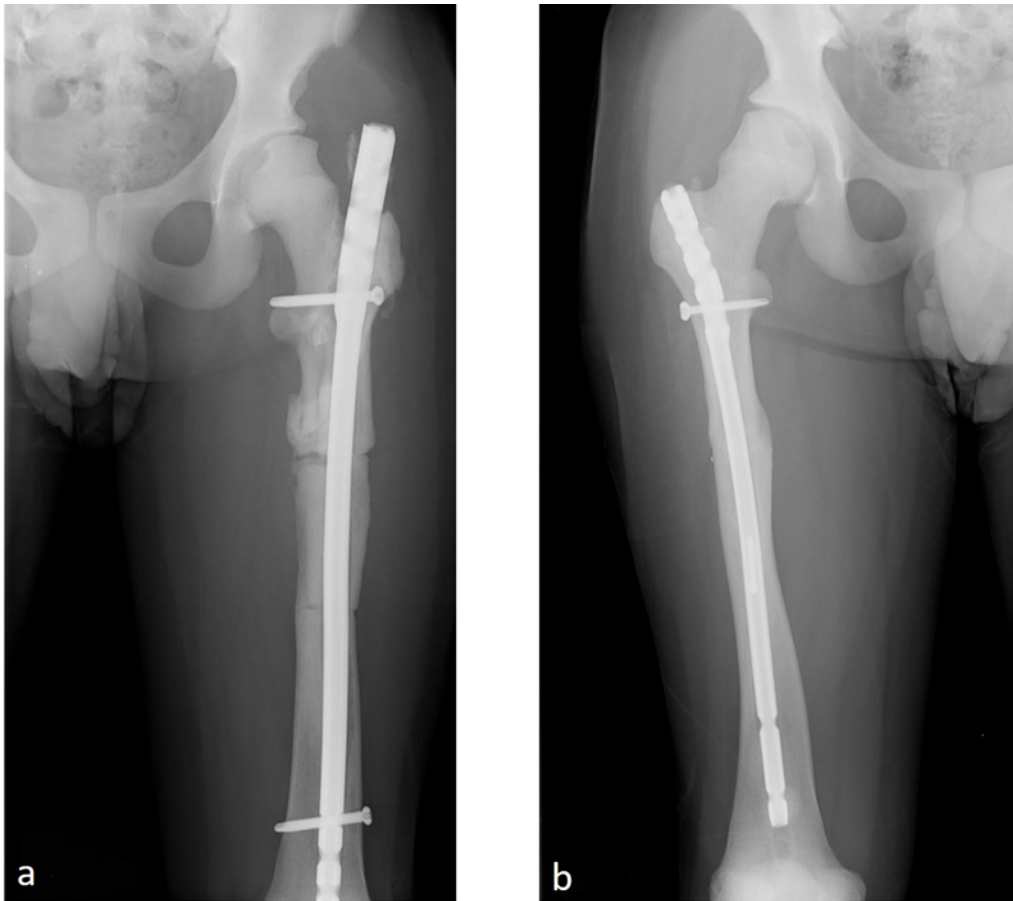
a) X-ray of the right femur performed at fourteen months from surgery; b) X-ray of the left femur performed at five months from surgery.
